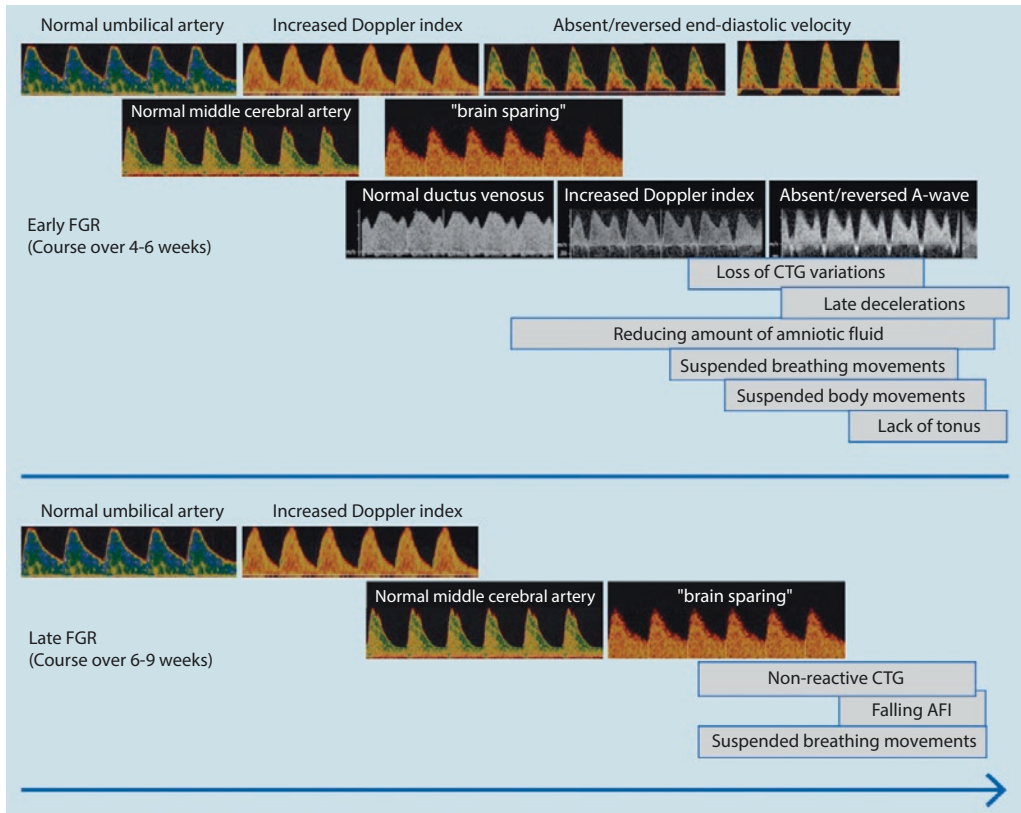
Clinical progression in early and late FGR. In early onset FGR, there may be a rapid or somewhat slower progression, depending on placental blood flow resistance. Arterial and venous Doppler changes often occur sequentially and are followed by
